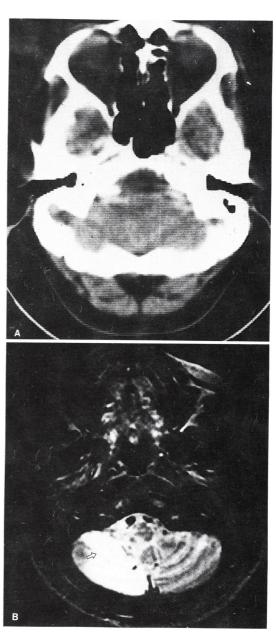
Brain CT of Case 16 has no lesion in the medullocerebellum, while MRI demonstrates a right lateral medullary infarction (arrow) and a large infarction in the right posterior inferior cerebellar artery territory.
